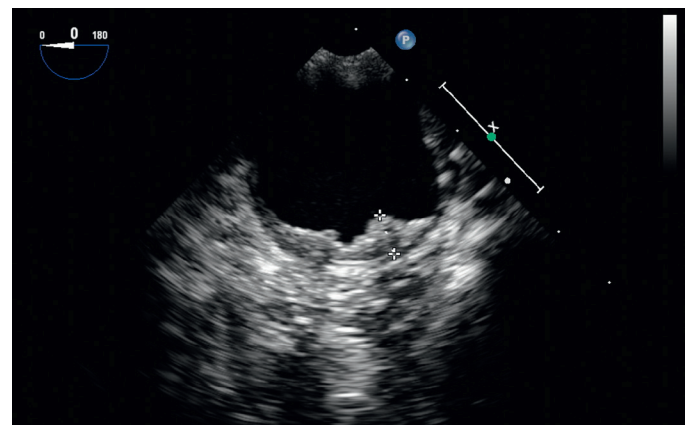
■ Transesophageal echocardiogram image showing an aortic plaque measuring 57 mm.
